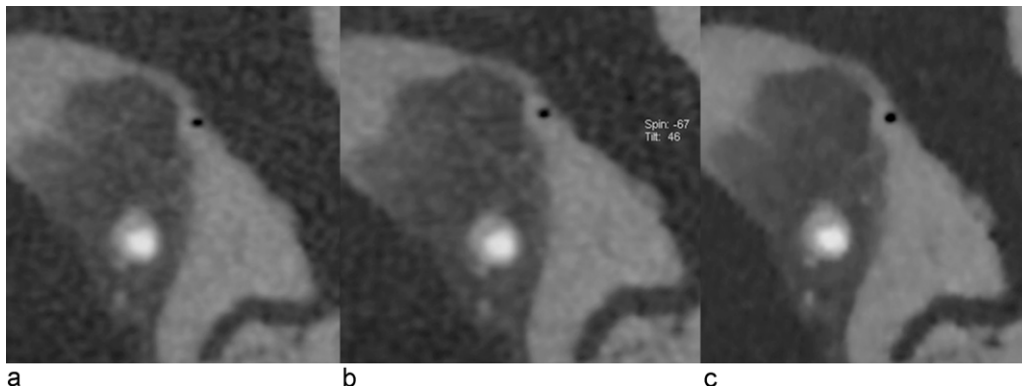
Cross-sectional CT image reconstructed with (a) FBP, (b) ASIR, and (c) MBIR technique. Note the substantial reduction (b) in noise better sharpness vessel lumen and adjacent vessel wall in (c) compared with (a) and (b).
